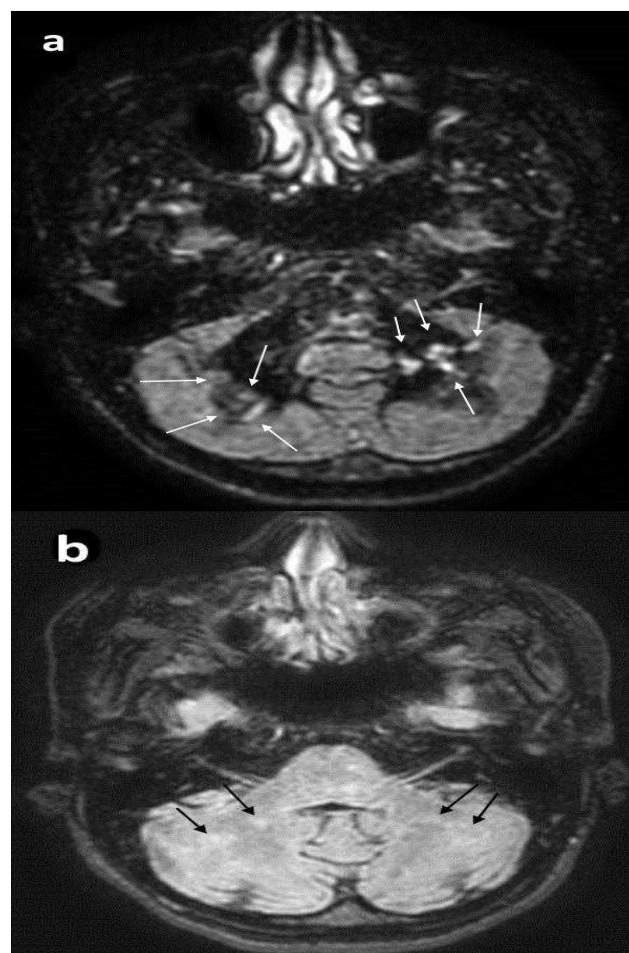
Cerebellar lesions are much more numerous and more prominently seen in the axial DIR image (a) than in the axial FLAIR image (b).
